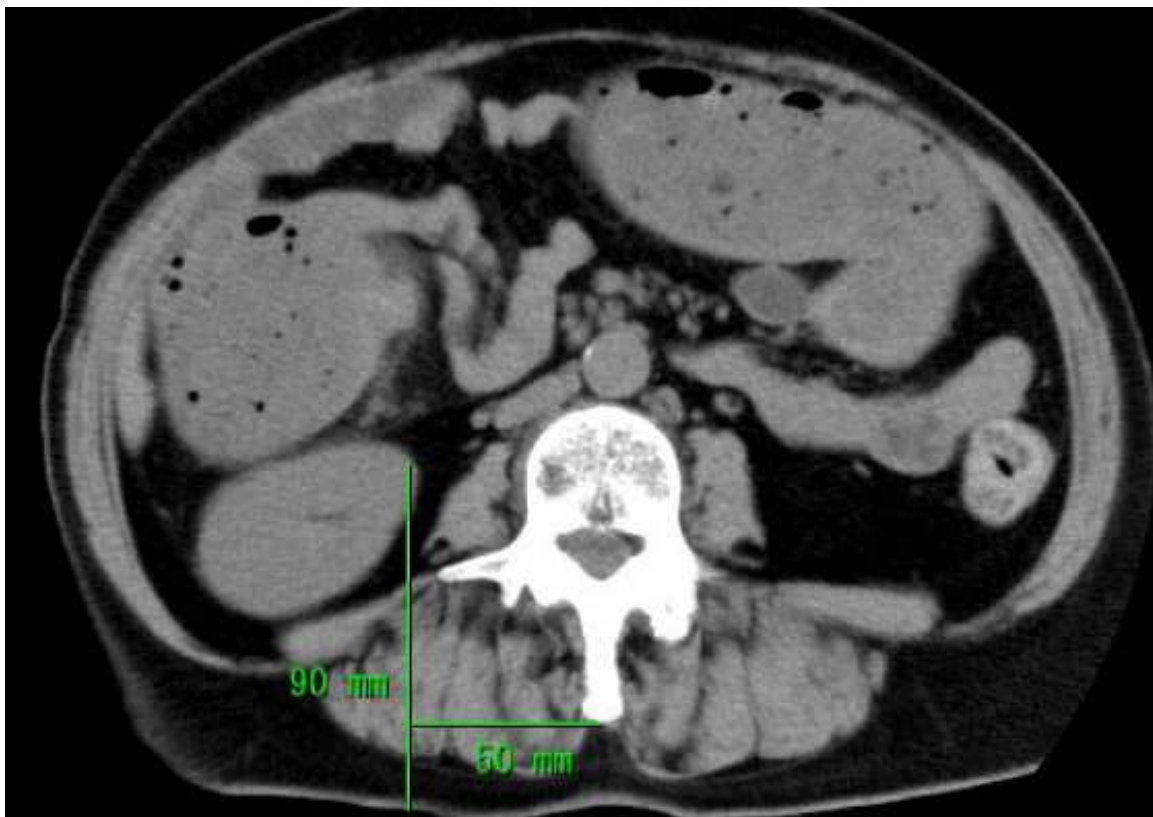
Computed tomography of the 4th lumbar spine level from a 62-year-old female. In these two cases, if the needle had been advanced as suggested by the textbook, an inadvertent renal puncture would have developed.
